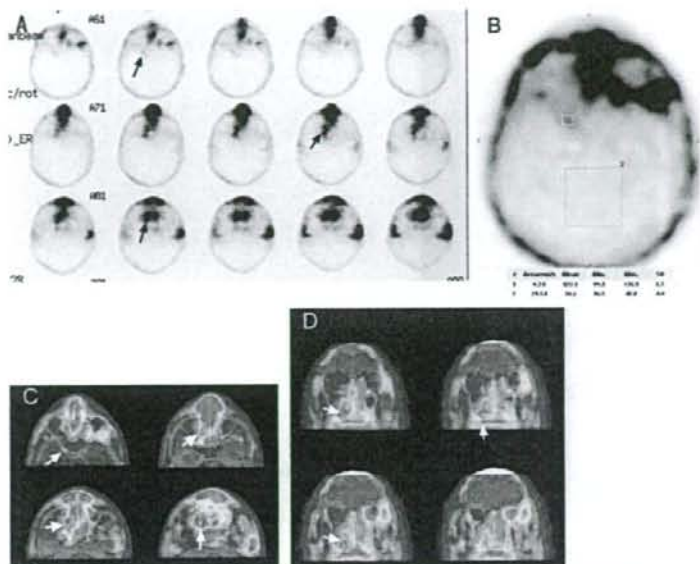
After informed consent was obtained from the patient, thallium-201 (Tl-201) SPECT/CT was performed to evaluate tumor extent and viability after therapy. SPECT showed abnormal uptake near the right Meckel's cave and posteromedial portion of the right maxillary sinus extending into the right palate (A, arrows). The count ratio between the former lesion and normal brain was 4.1 (B). SPECT/CT image fusion technique was reported previously.¹ Fusion images showed precise location of the abnormal uptake sites (C and D, arrows). Coronal SPECT/CT images show abnormal uptake extending from the medial portion of the right maxillary sinus to the right palate (D, arrows). No pathologic uptake is noted around the right orbit. There are some case reports concerning application of nuclear imaging in the evaluation of PTI. Fluorine-18 fluorodeoxyglucose (FDG) PET fused with CT has been useful to detect PTI in patients with squamous cell carcinoma of the lip.^{2,3} Fosko et al⁴ reported a patient with basal cell carcinoma of the head and neck in which FDG PET failed to detect PTI. The absence of Tl-201 uptake by bony structures such as the skull base contributes to the high tumor-to-nontumor ratio,⁵ which may enhance usefulness of SPECT/CT image fusion for precise localization of viable PTI.
